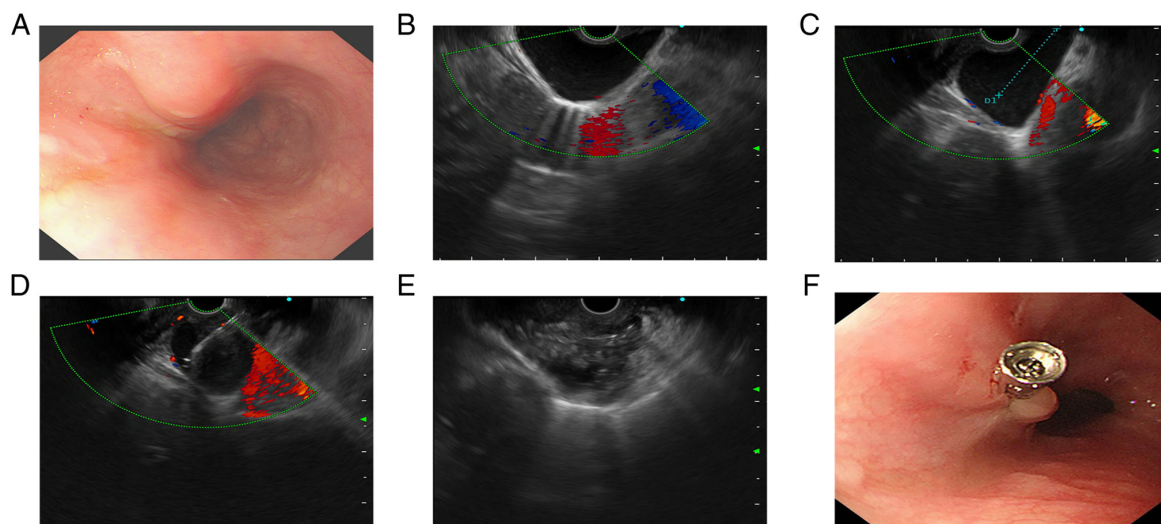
Endoscopic images of mediastinal cyst. (A) Gastroscopic image prior to puncture. (B) Endoscopic ultrasound image prior to puncture with no echo and no flow signal. (C) Localization prior to EUS-FNA. DI indicates the puncture distance of the needle. (D) During EUS-FNA. (E) Following EUS-FNA. (F) Gastroscopic image following puncture. EUS-FNA, endoscopic ultrasound-guided fine needle aspiration.
